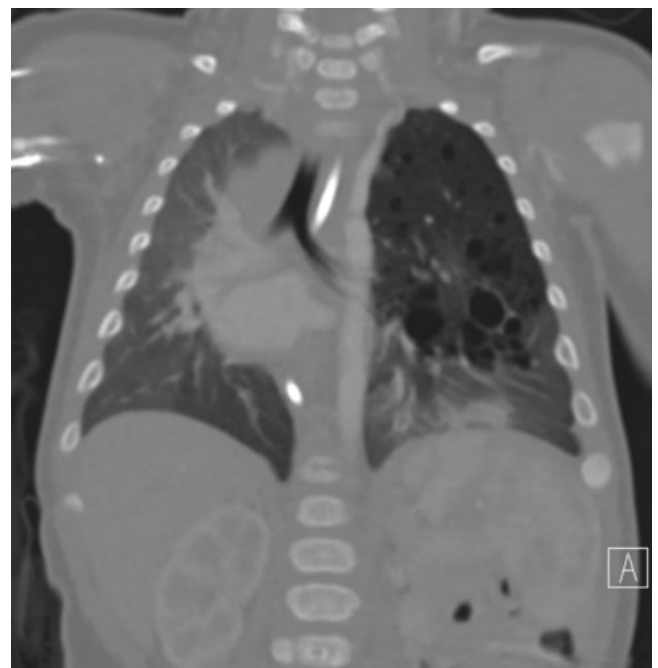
Chest CT of a newborn with congenital pulmonary airway malformation (CPAM).
